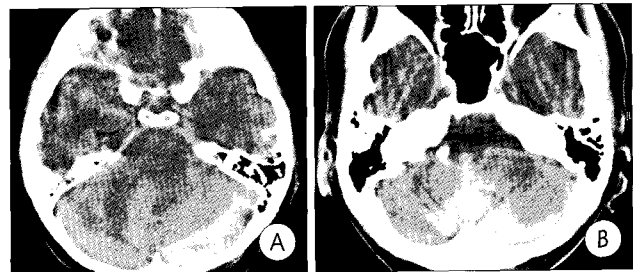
Case 1 and 2. A : Initial noncontrast computed tomography(CT) showing the subdural hematoma(SDH) with 2cm thickness in the left cerebellar hemisphere. Both 4th ventricle and cisterns around the brain stem are not visible (case 1). B : Initial noncontrast CT showing the midline SDH in the posterior fossa (case 2).
